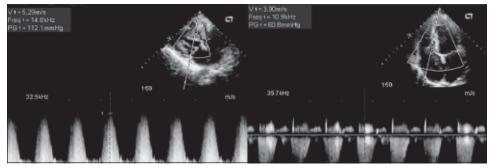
2-D and CFM guided CW-Doppler in parasternal long axis (left) and apical 4-chamber (right) view showing high gradient Doppler signal across VSD.
